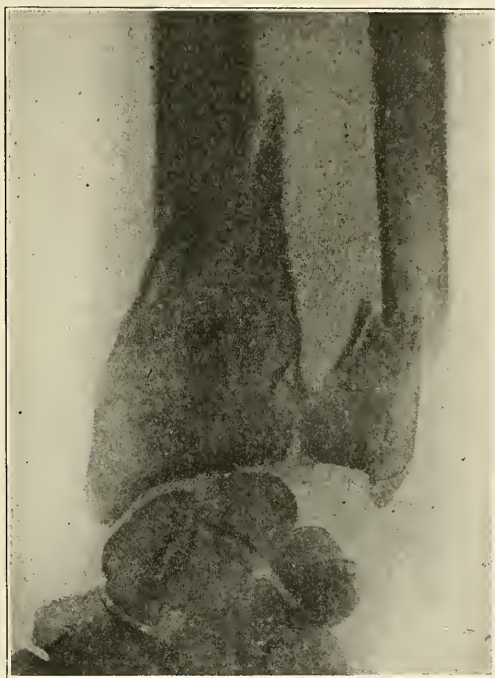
X-ray showing fracture of both bones of the forearm. (Park.)
